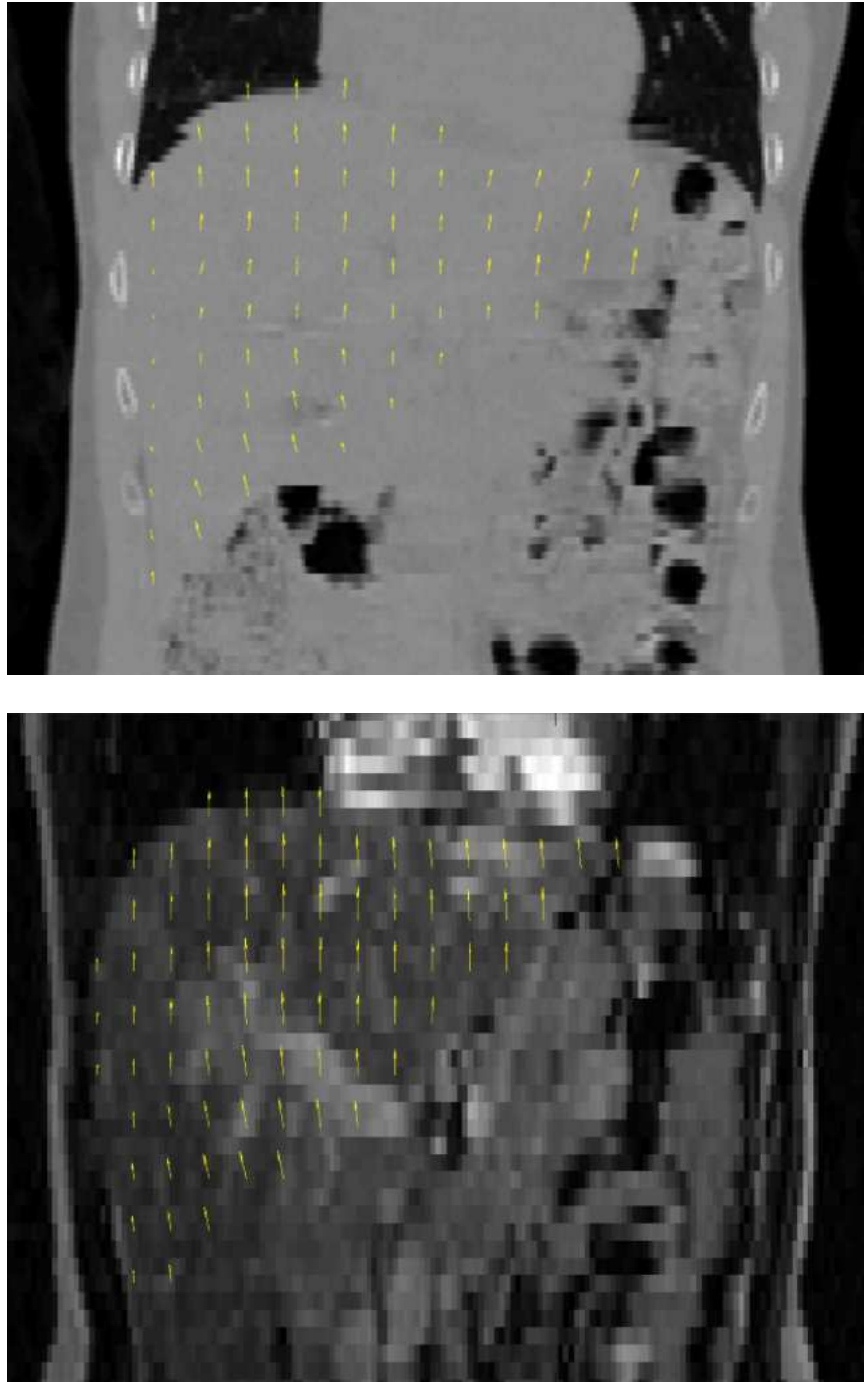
DVFs from 4D CT (top) and 4D MRI (bottom) between the EOI and the EOE phase in the coronal view in the liver.
